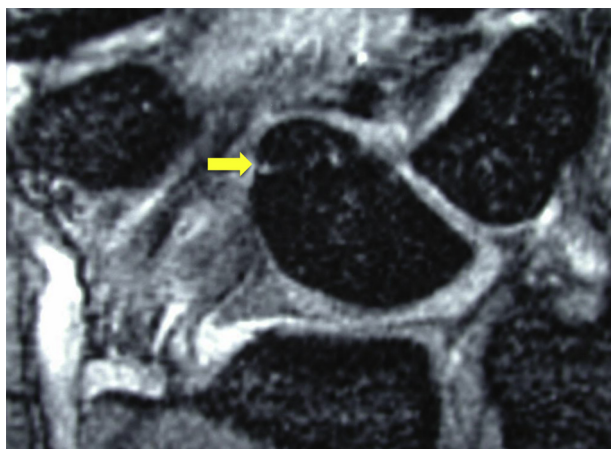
Magnetic resonance image of a volar chip fracture of the lunate (arrow).
